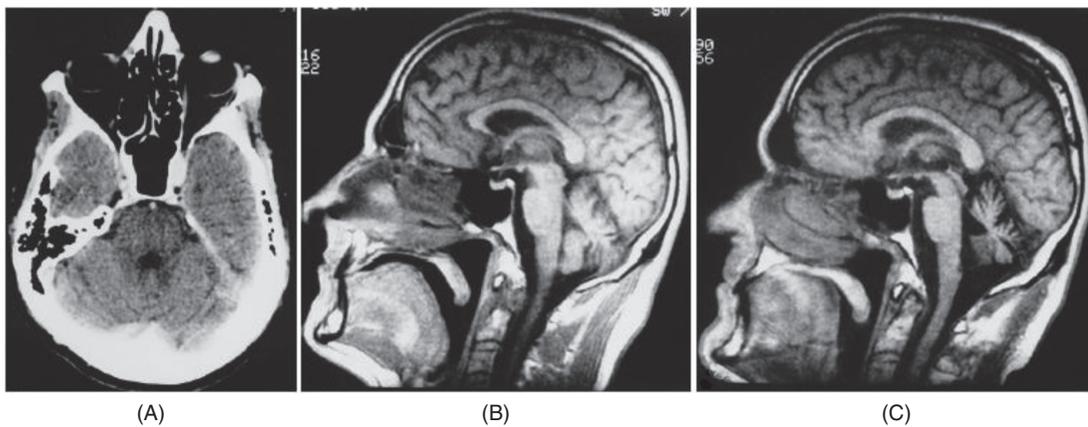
Cerebellar atrophy is a common heat stroke response shown by computer tomography (CT) scan. A 45-year-old man was unconscious and hyperthermic with convulsions at the time of hospital admission. (A) Cerebellum appeared normal 2 weeks following collapse, but showed progressive atrophy from 10 weeks (B) to 11 weeks (C) of recovery. Hypothalamic damage was not reported in this patient. *With, kind permission, from Springer Science and Business Media (12).*
